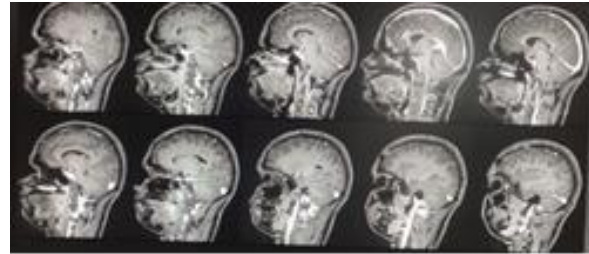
Post operative MRI Brain with contrast after second surgery at 1 month follow up.
